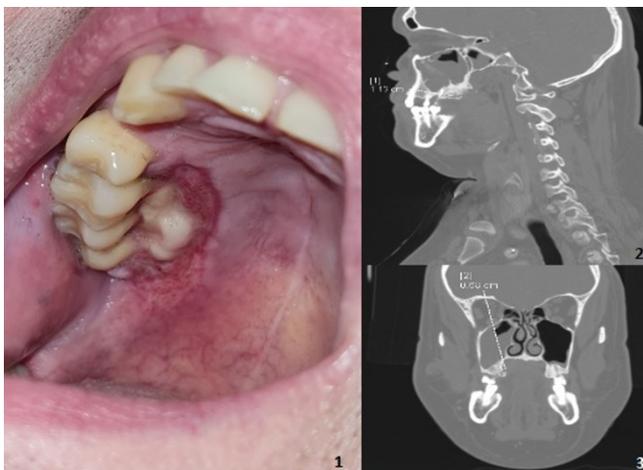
CT imaging of a bone sequestrum with chronic inflammation of mucosa.
